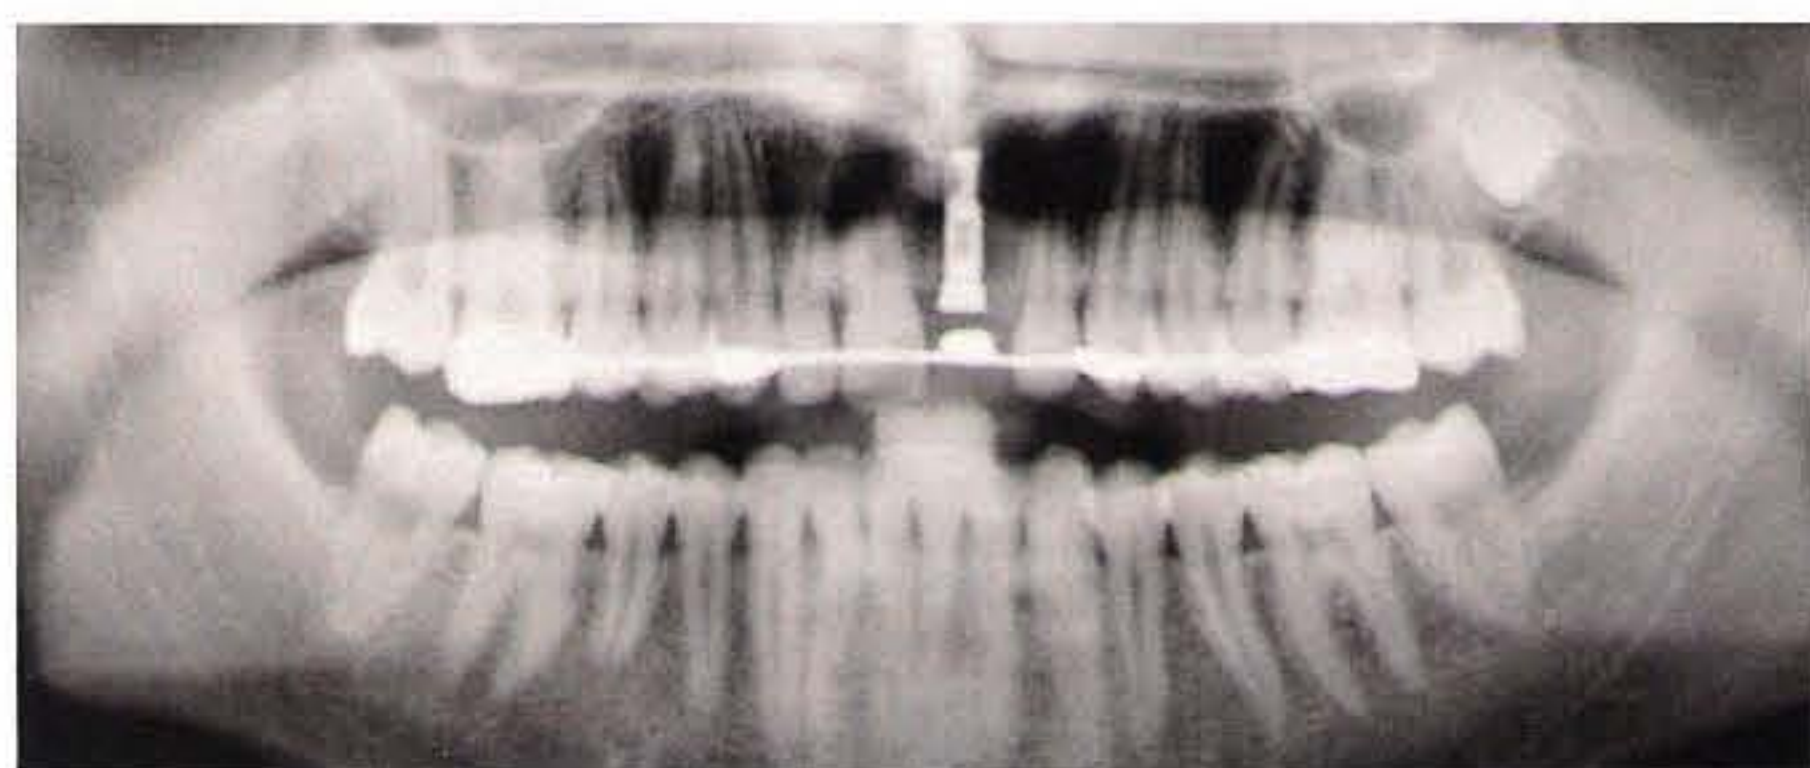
A panoramic radiograph is used for assessment of the implant after 6 months.
